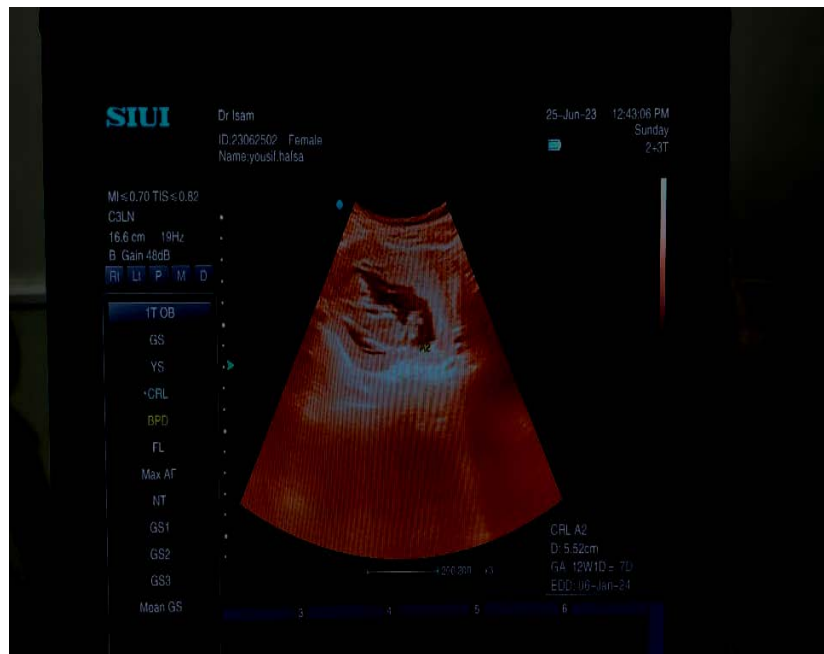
First ultrasound picture after pregnancy.
